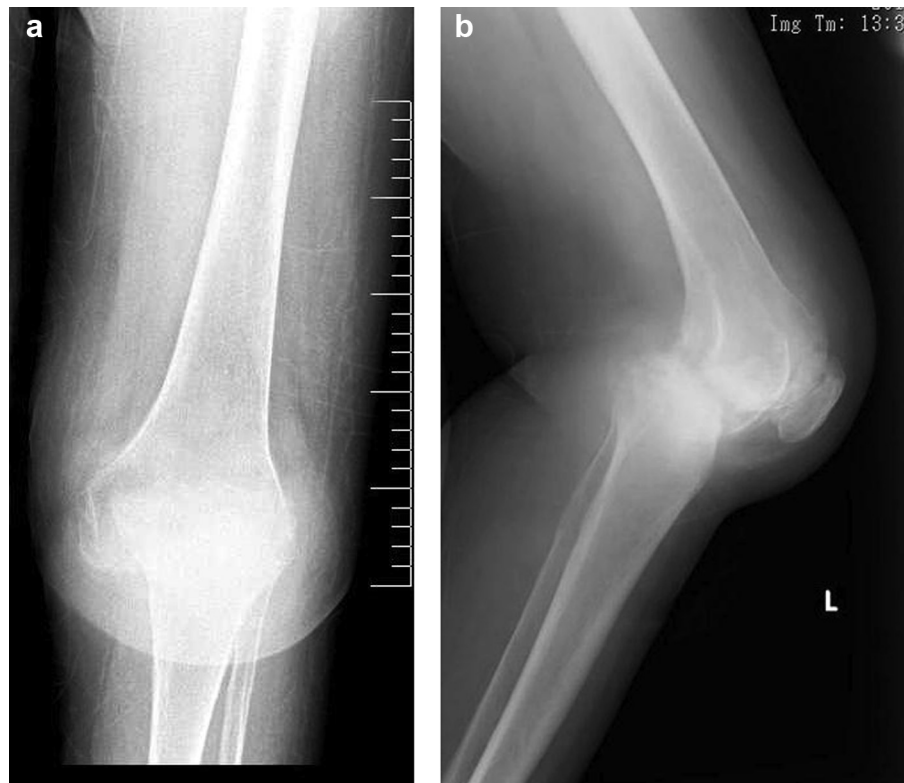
(a) Anteroposterior and (b) lateral radiographs demonstrate posterior dislocation of the knee.
